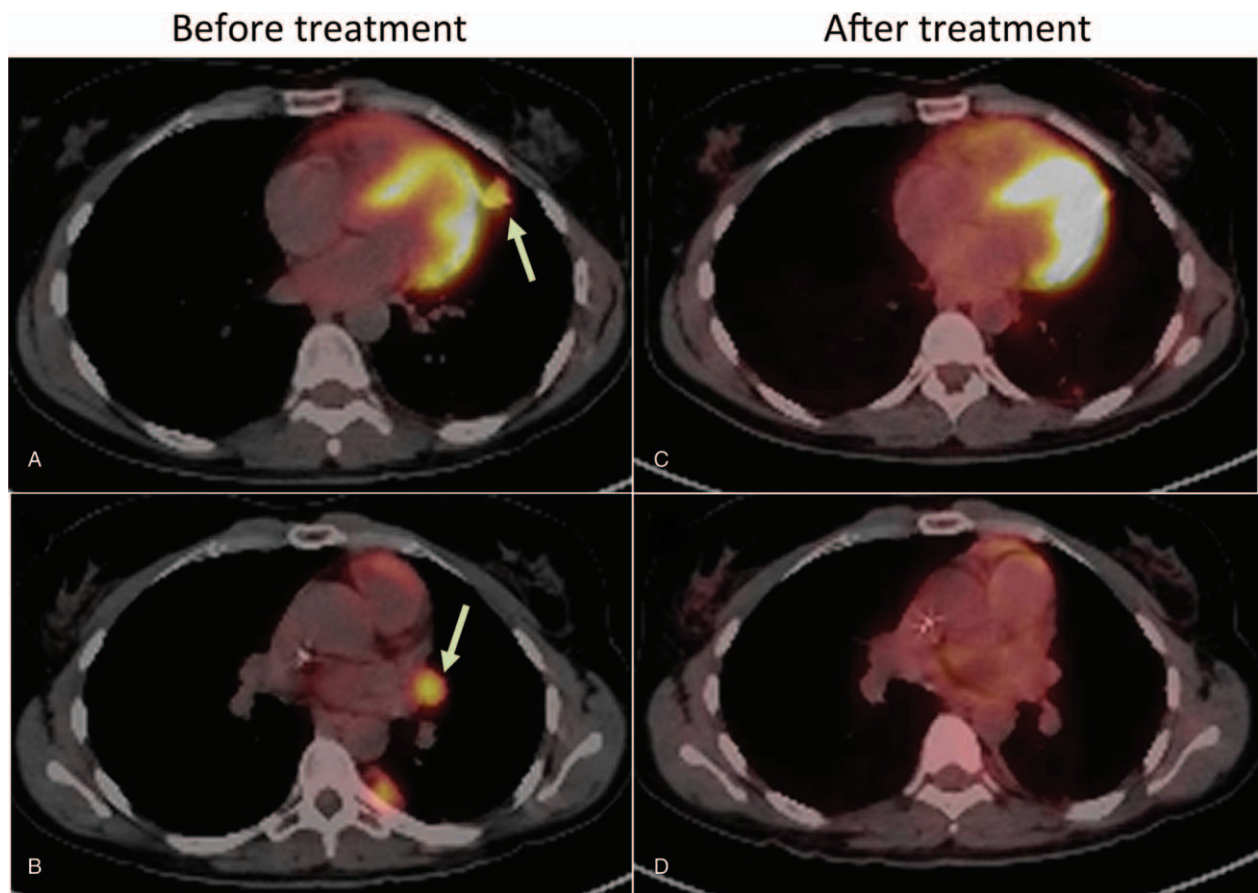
Representative cross-sectional fusion images of ¹⁸F-FDG PET scans before and after pembrolizumab treatment in Case #1. Cross-sectional images showing hypermetabolic pulmonary nodule and hilar lymph node before (A and B) and after (C and D) treatment with pembrolizumab. Arrows point towards hypermetabolic lesions.
